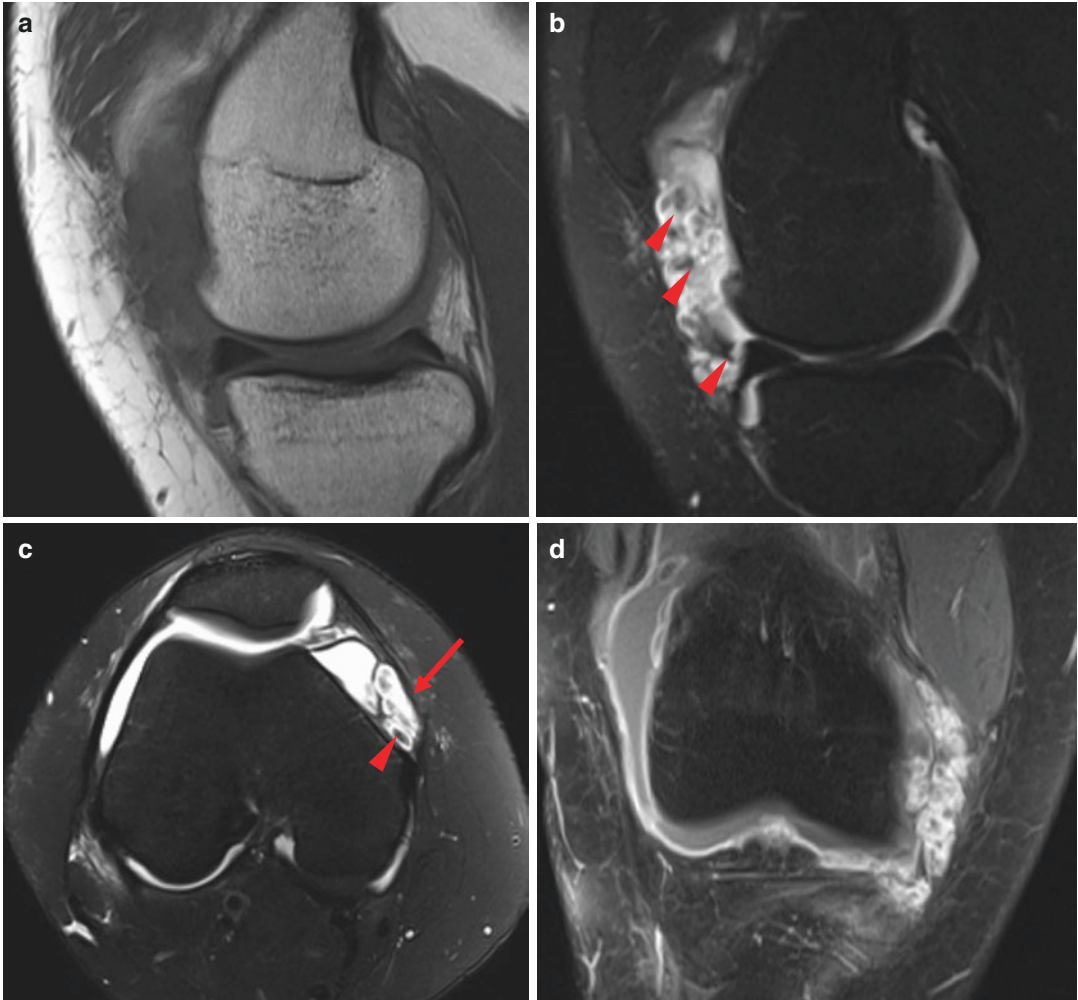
Synovial hemangioma. MR image of the knee shows a multilobulated, multiloculated intra-articular soft tissue mass (*arrows*) with inhomogeneous hyperintensity relative to muscle on T1WI (a) and heterogeneous hyperintensity on FS T2WI (b, c). The lesion is located along the synovial surface of the medial suprapatellar bursa.
